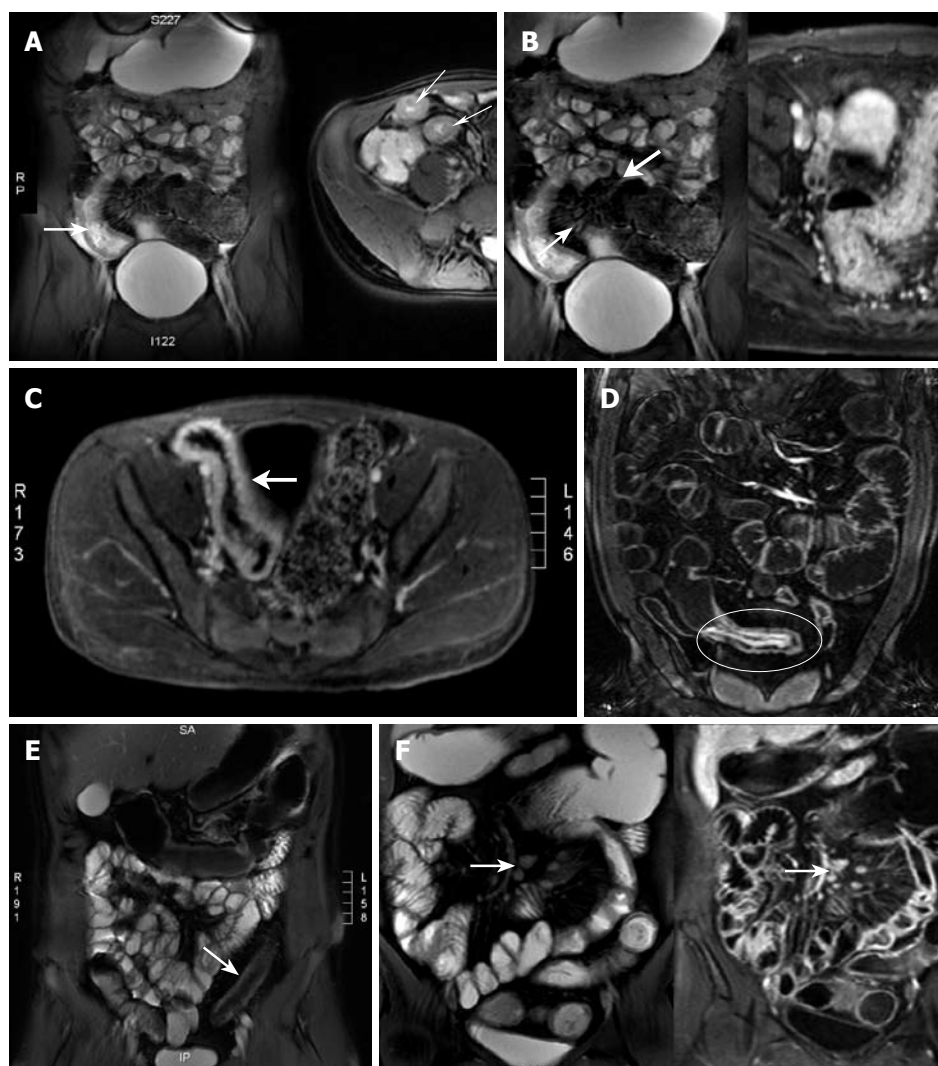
MRI characteristics of intestinal inflammation. A: Bowel wall thickening. The distended bowel wall is normally 1-3 mm thick. An abnormal thickness is > 4 mm (arrowed); B: Mucosal hyperemia (thick arrow), engorged ileal vasa recta or the "comb sign" (thin arrow); C: Transmural enhancement (arrowed); D: Mucosal enhancement (circled); E: Fibrofatty infiltration (arrowed); F: Lymphadenopathy (arrowed).
